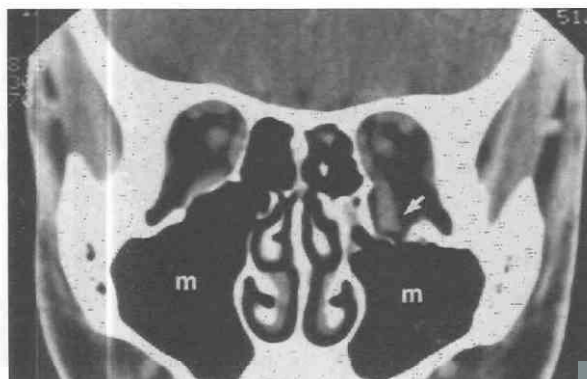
CT scan shows blowout fracture of the left orbital floor with herniation of extraconal fat and inferior rectus muscle (arrow). m, maxillary sinus.
